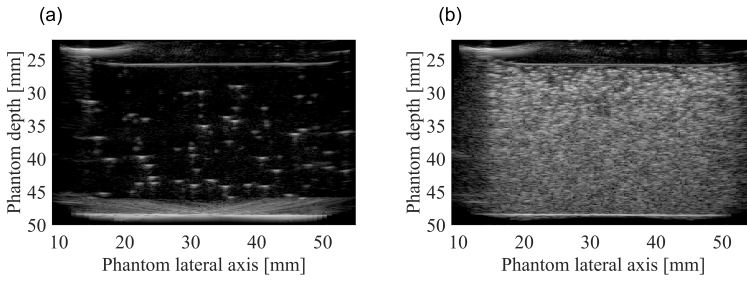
Ultrasound images of polyacrylamide gels with (a) dispersed PVA-PFB nanodroplets or (b) PCDA-PFB nanodroplets, after heating to 37 °C through immersion in a warm water bath (no irradiation).
